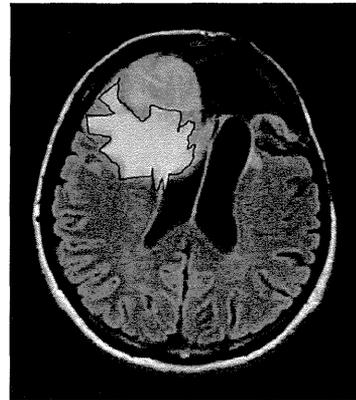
The area of hyperintensity was manually outlined on each FLAIR MR image (black line).
